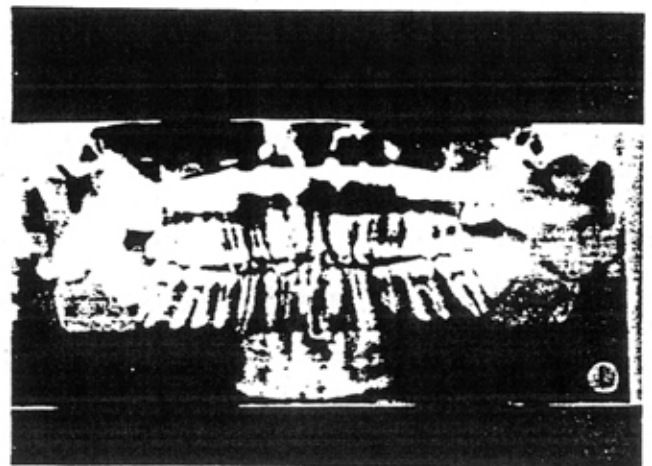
Panoramic radiograph demonstrating impacted third molars in a college football player.
